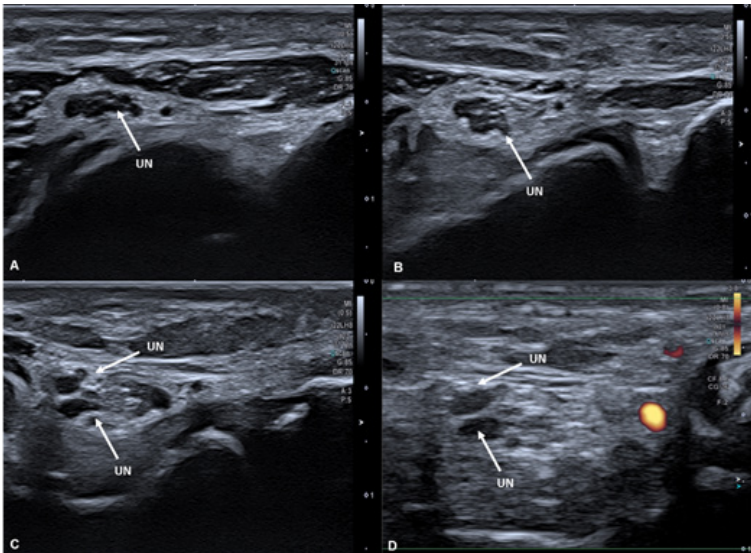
Right Elbow Ultrasonography Transverse Cut: Ulnar nerve at different levels of its course going distal to proximal (1A to 1D). It starts with its usual unique configuration (1A and 1B) and then starts to split (1C). Through Fig. 1D it is possible to distinguish the ulnar nerve (without Power Doppler signal) from blood vessels (with Power Doppler signal).
